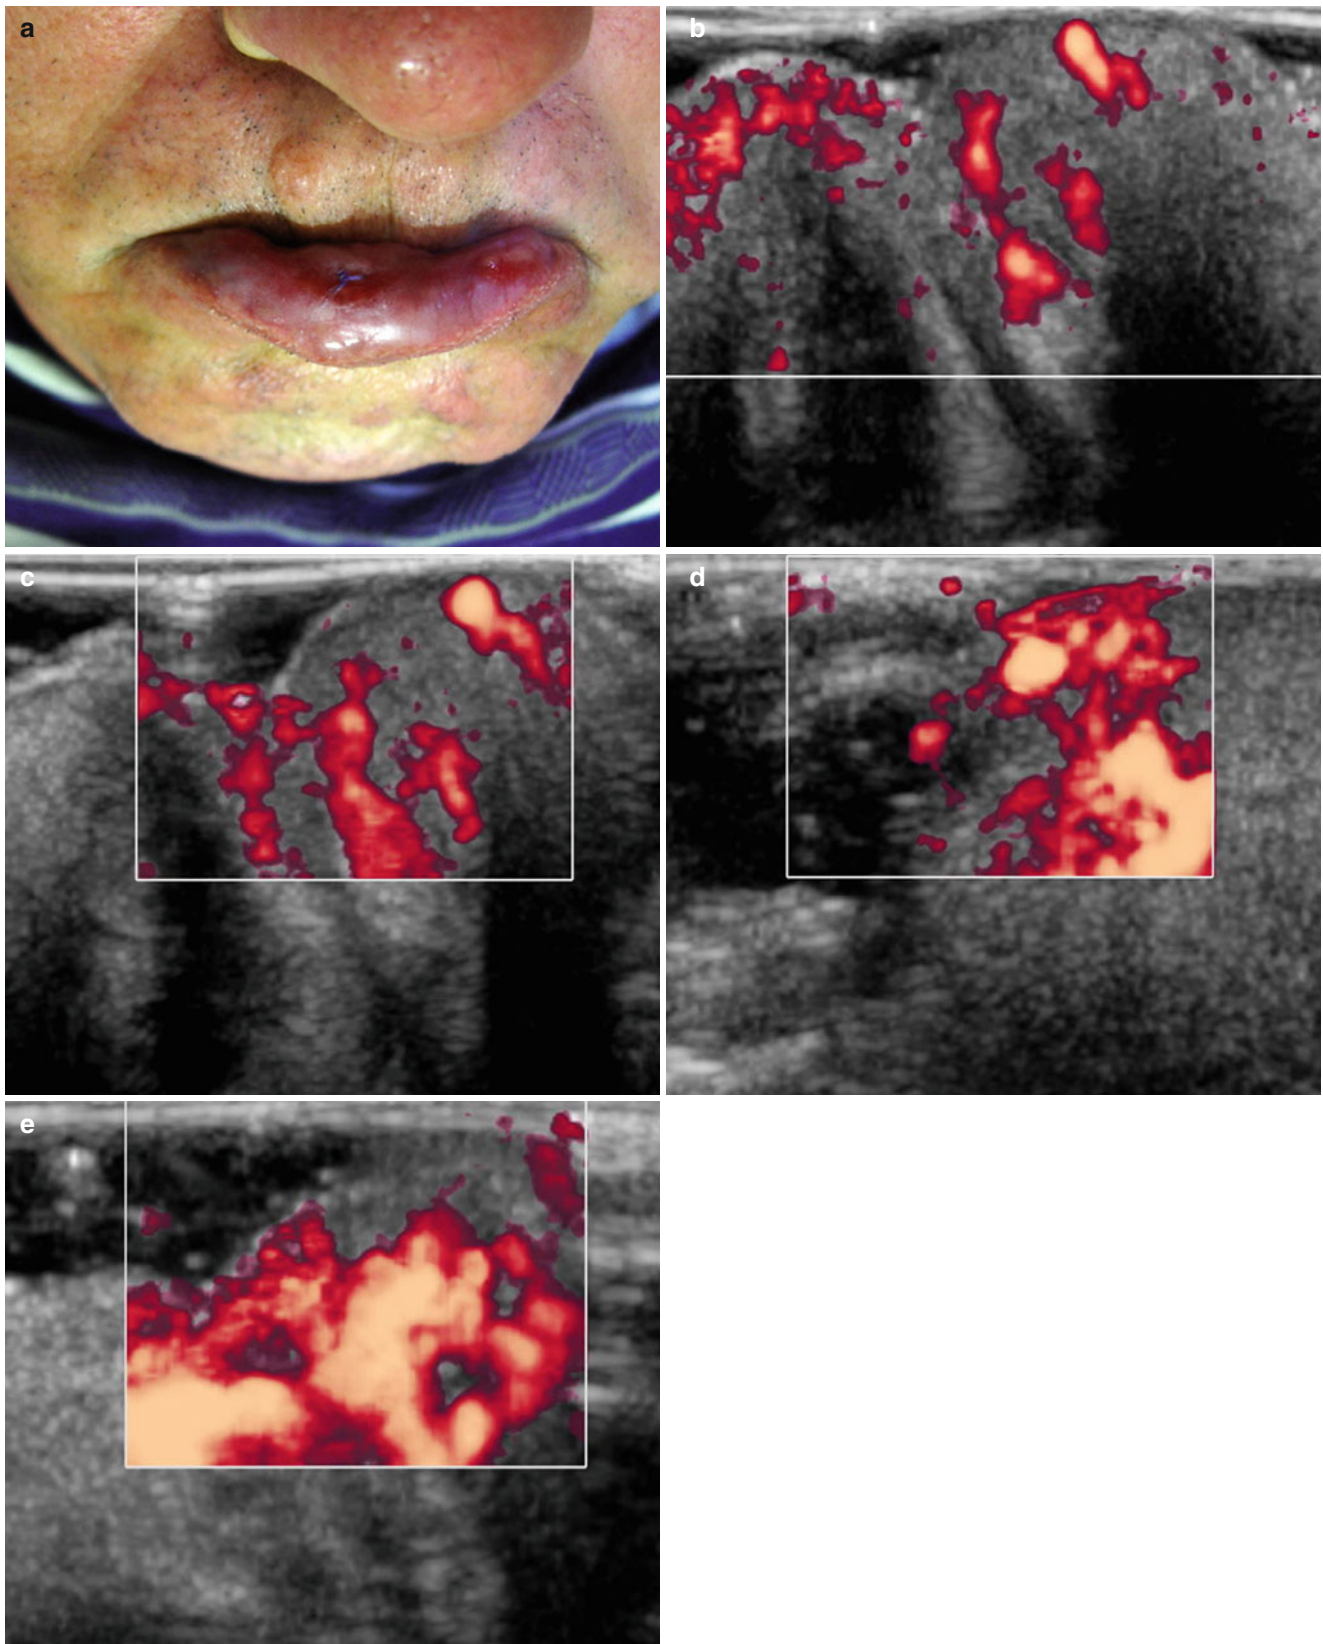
(a) Lower lip squamous cell carcinoma. (b, c) Power Doppler ultrasound image before contrast—some vessels seen in central and peripheric region. (d, e) Power Doppler ultrasound image after contrast—lesion better seen after contrast, hypervascularized
